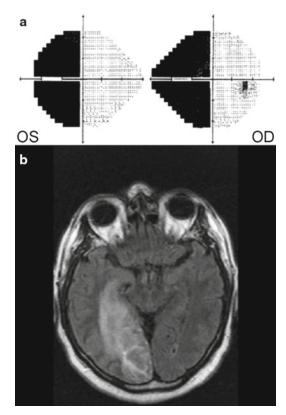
Left homonymous hemianopia secondary to a right occipital infarction. (a) Humphrey visual fields showing a complete left homonymous hemianopia. (b) Axial FLAIR MRI of the brain showed a right occipital infarction in the territory of the right posterior cerebral artery
